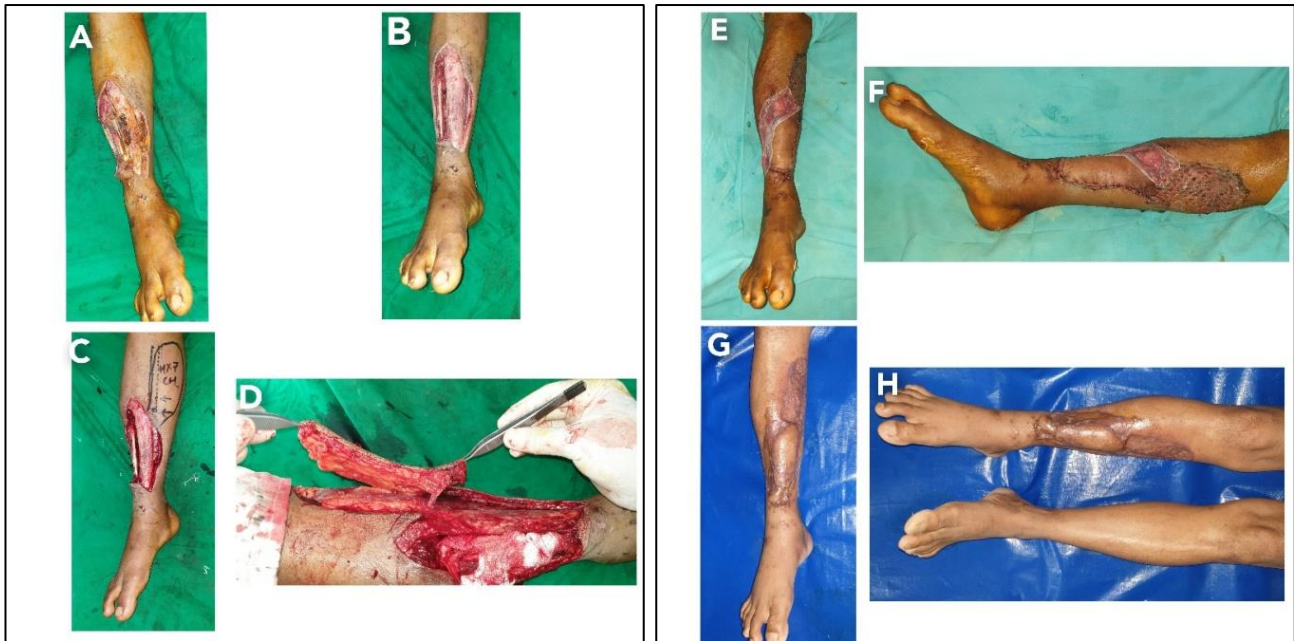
Posterior Tibial Artery Perforator Flap coverage in the Right Leg with exposed tibia. A, Initial defect in the right leg. B, Wound after Excision of necrotic tissue. C, Designing of Posterior tibial artery perforator flap and detection of perforators done by Doppler ultrasound. D, Elevation of Flap on a single best perforator. E & F, after flap inset. G & H, 3 months after operation
